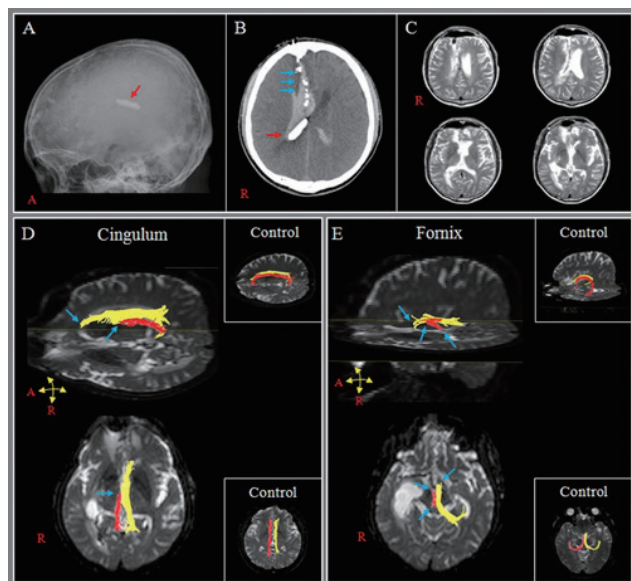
Brain CT, MRI, and results of diffusion tensor tractography.
